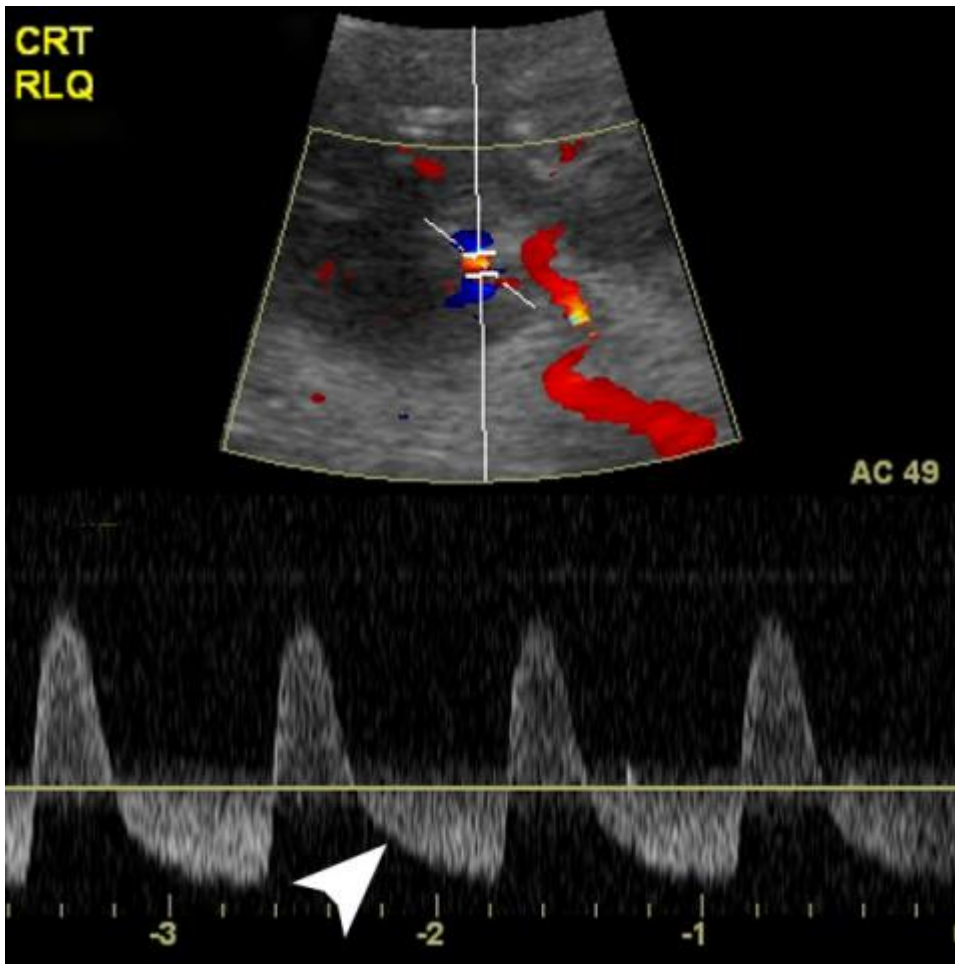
Renal vein thrombosis. Spectral Doppler image shows reversed diastolic flow (arrowhead) due to renal vein thrombosis
